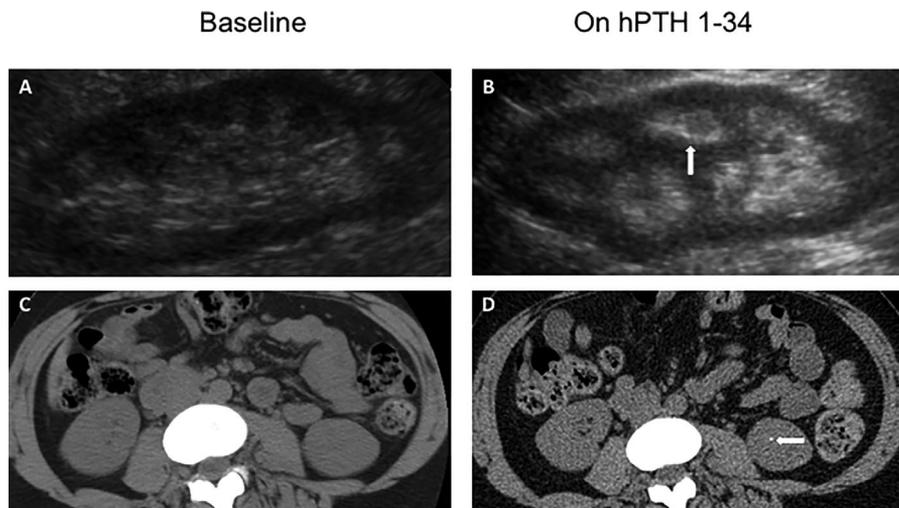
Renal imaging in hypoparathyroid subjects treated with human parathyroid hormone (hPTH) 1-34. Top panels: (A) normal renal ultrasound in a 40-year-old man with hypoparathyroidism due to an activating mutation of the calcium-sensing receptor (CaSR) on conventional therapy for over 20 years; (B) medullary nephrocalcinosis (arrow) is seen after 1 year of hPTH 1-34 (Subject #16 in Supplemental Table 1). Bottom panels: (C) normal renal CT in a 34-year-old woman with postsurgical hypoparathyroidism on conventional therapy for 6 years; (D) asymptomatic nephrolith seen (arrow) after 3 years of hPTH 1-34 (Subject #3 in Supplemental Table 1).
